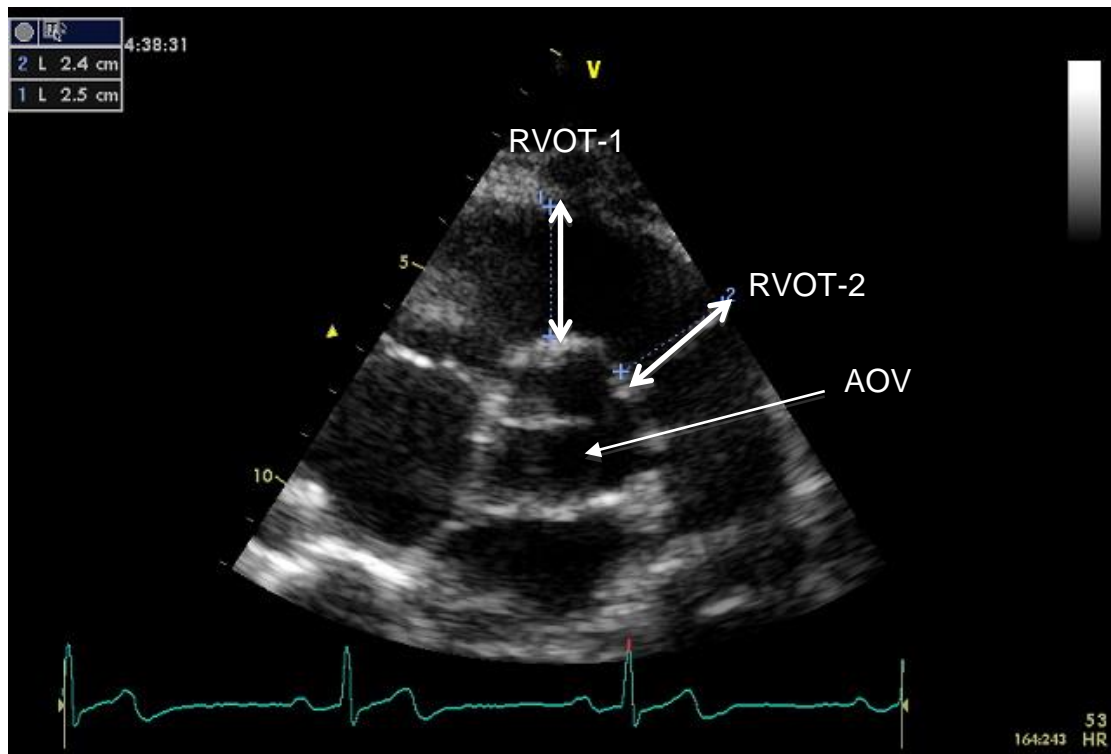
Parasternal short axis view assessed at the aortic valve level
